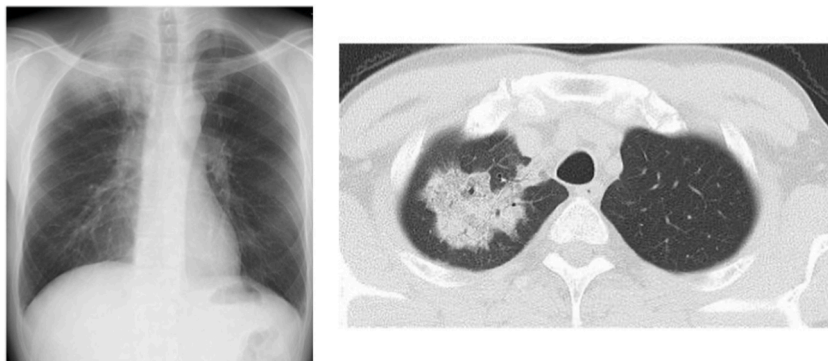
Chest X-ray and computed tomography images
